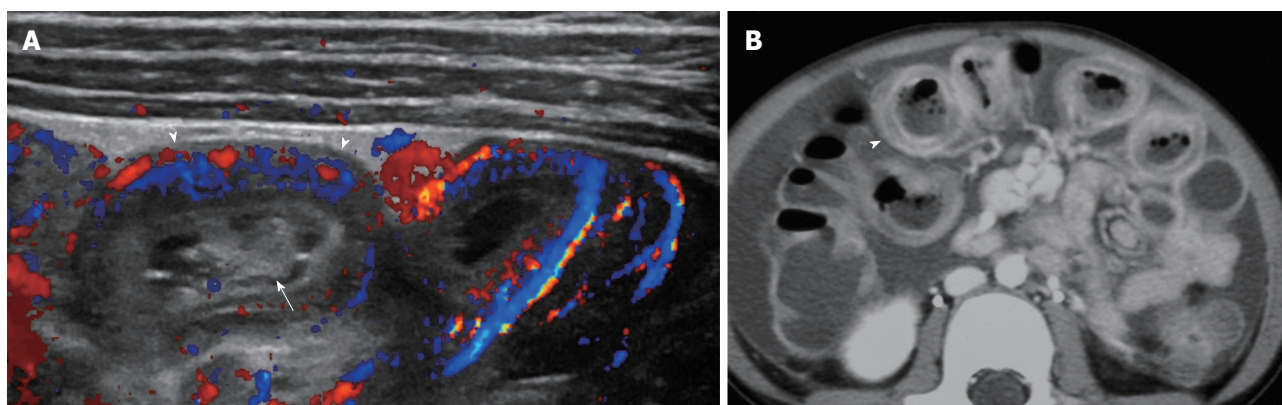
Henoch Schonlein purpura. Seven-year-old boy with purpuric rash and abdominal pain. Ultrasound image with color Doppler shows thick walled and hyperemic small bowel loops (A, arrowheads) and small bowel-small bowel intussusception (A, arrow). Computed tomography shows stratified enhancement of thick walled small bowel with submucosal edema (B, arrowhead).
